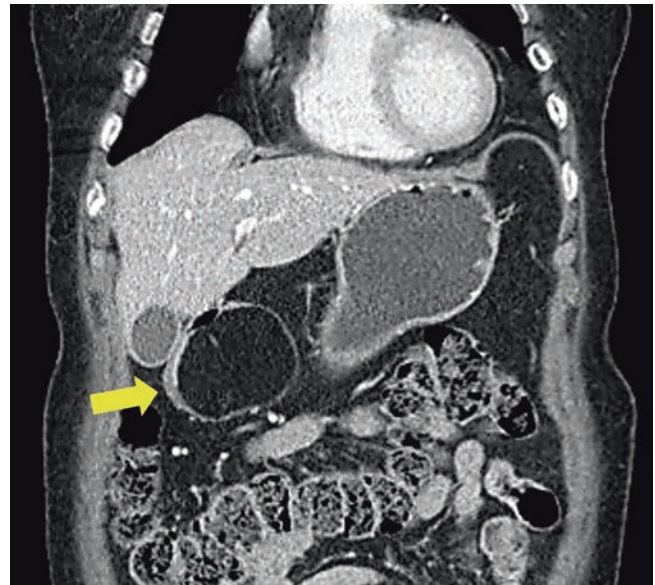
Computed tomographic finding of duodenal lipoma (yellow arrow). It shows an overall hypodense homogeneous low signal lesion
